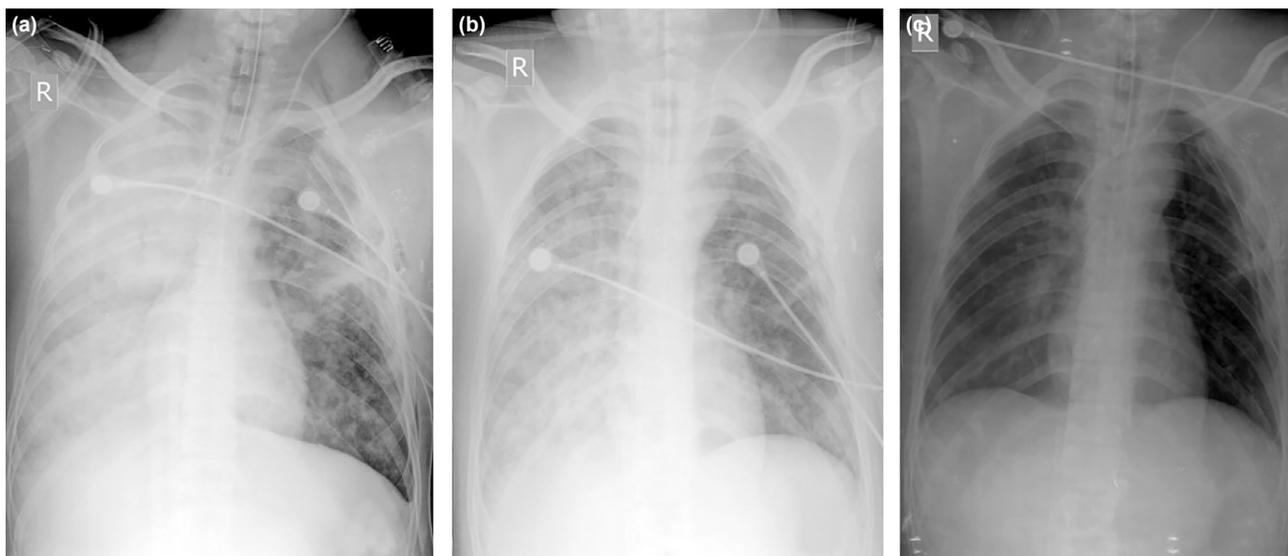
Serial X-ray findings showing gradual improvement after the operation. (a) Operation day, (b) Post-operative day 1, and (c) Post-operative day 2.
